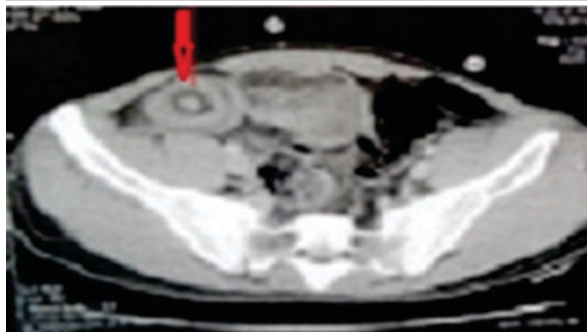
A Contrast enhanced computed tomography scan showing typical target sign.
